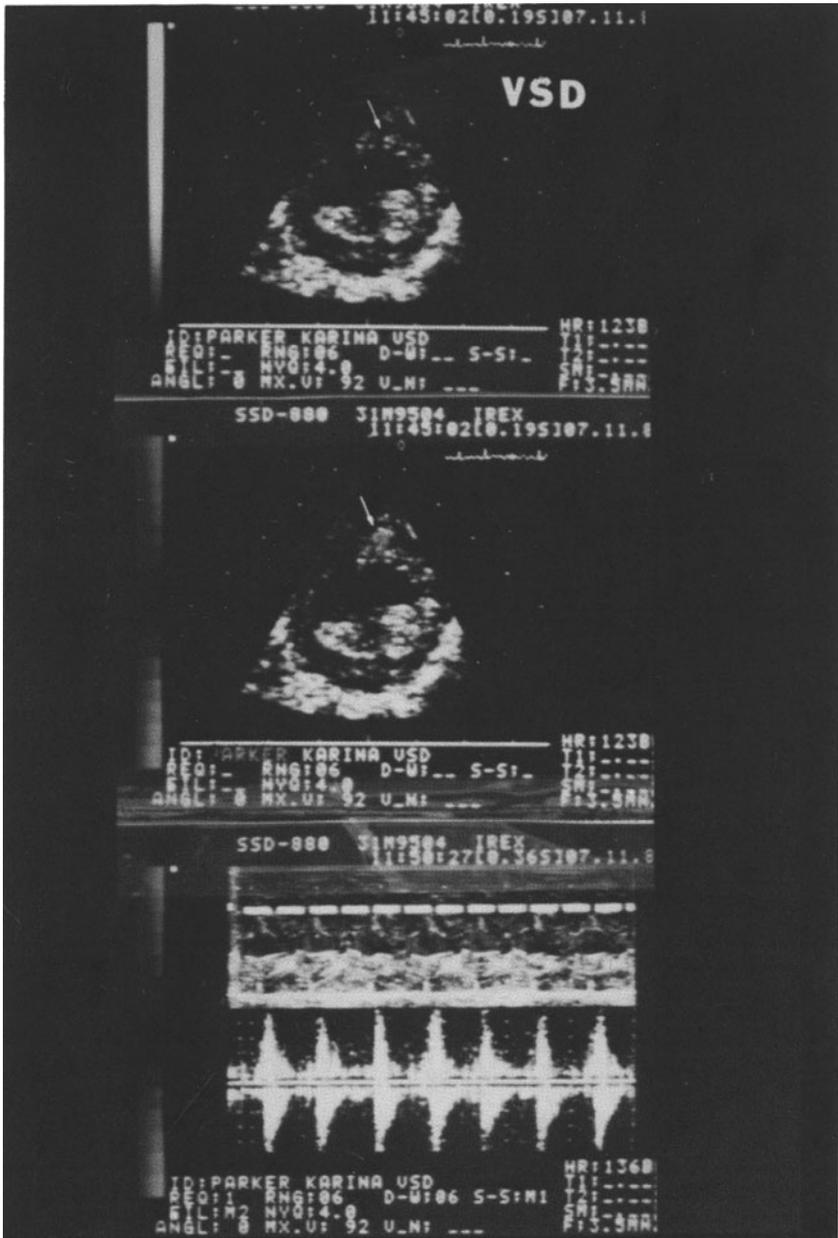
Example of color Doppler flow mapping shows imaging of a very small ventral septal defect that is barely discernible on the two-dimensional echo, but the flow coming towards the transducer color encoded as orange can be clearly seen coming from the left ventricle into the right ventricle in the short-axis view in the middle panel. When the sample volume is placed in the area where the shunt has been imaged on the flow map, the characteristic waveform Doppler of high velocity turbulent flow coming towards the right ventricle is obtained.
